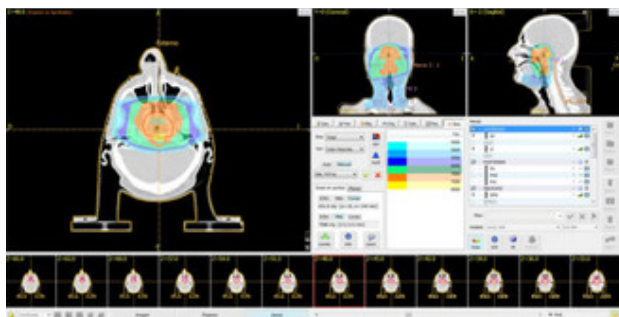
Depicts the CT 3D planning, revealing the destruction of the clivus and the bone barrier caused by the neoplasm.
